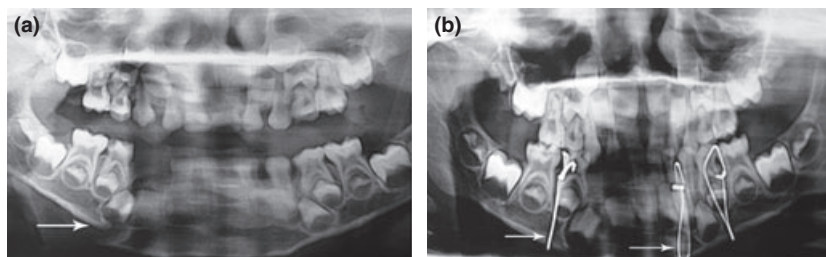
(a) Preoperative orthopantomogram (OPG) revealing fracture site. (b) Post operative OPG reveals fracture reduction and circummandibular wires *in situ*.
